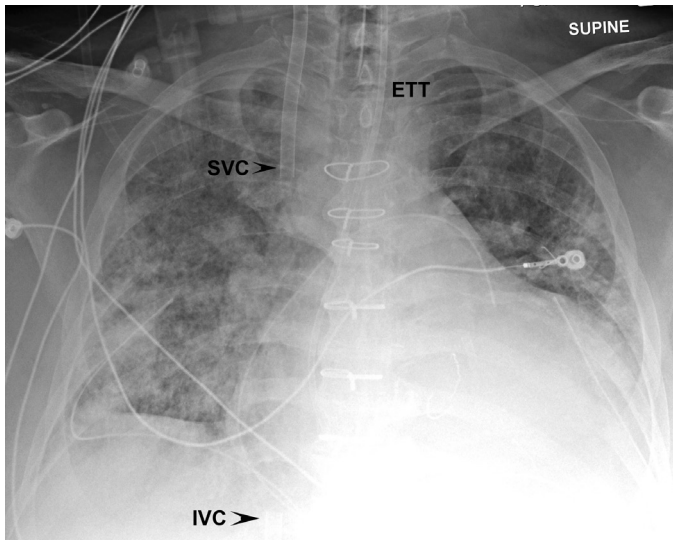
■ Anteroposterior (AP) supine chest x-ray. Diffuse bilateral airspace opacities in a patient with diffuse alveolar disease (DAD). Dual caval ECMO catheters noted in the SVC (superior vena cava) and IVC (inferior vena cava, marked with arrows). Bilateral chest tubes, ET tube, feeding tube, mediastinal drains, and mitral valve prosthesis also noted.
